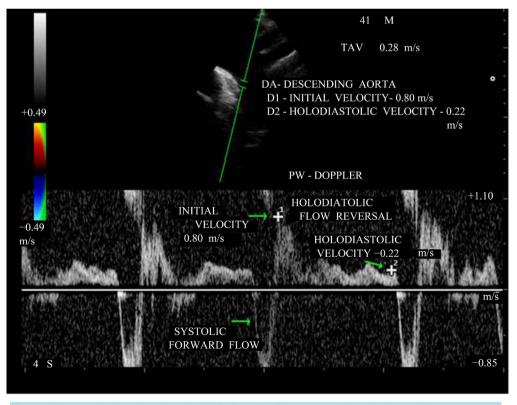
PW doppler showing the "holodiastolic flow reversal" in the descending aorta-suprasternal notch view).
